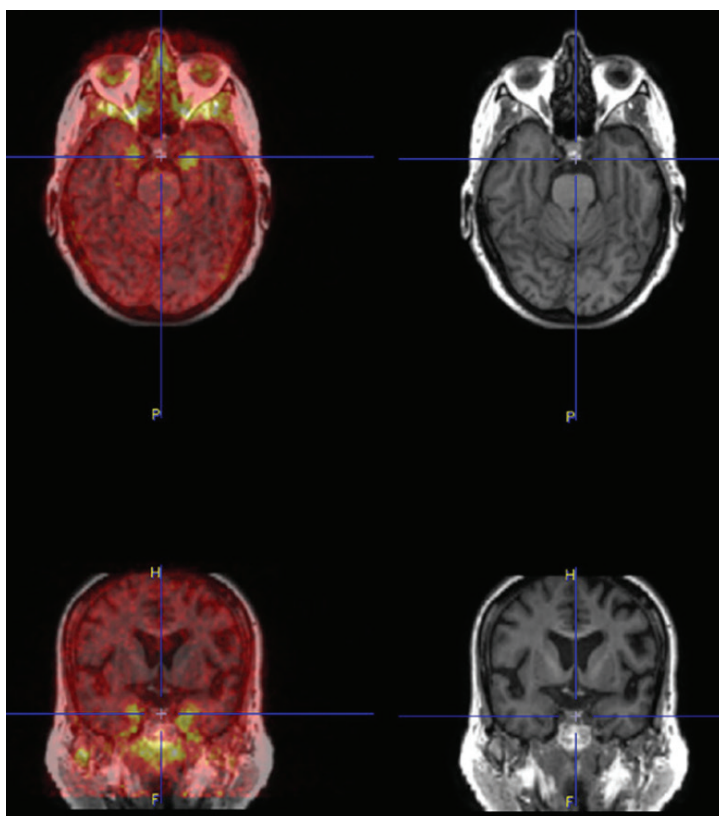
$^{18}\text{F}$ -MK-6240 PET fused with MRI in the left column and MRI in the right column demonstrate isolated accumulation of tau in the mesial temporal lobes indicative of early-stage tau accumulation (reprinted from ref. 3).
